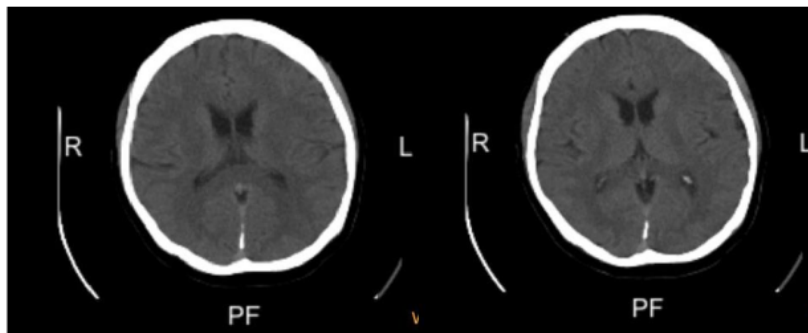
The brain CT scan of the patients, rule out brain metastases
